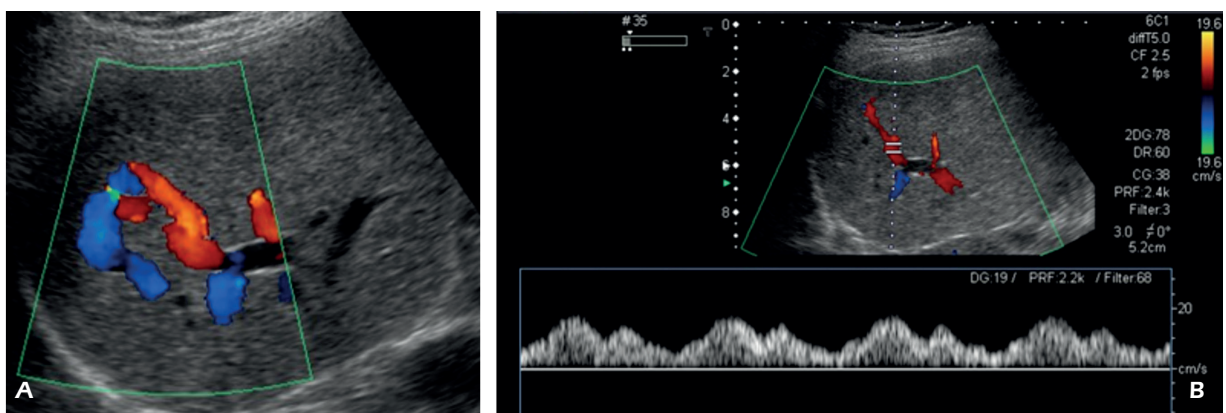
Congenital intrahepatic portosystemic shunts - type 2. A, Color Doppler US shows a communication between peripheral portal and hepatic veins in segment VII. B, The Doppler waveform of the portal vein is abnormal and shows cardiac modulation due to the direct communication with the central venous system
